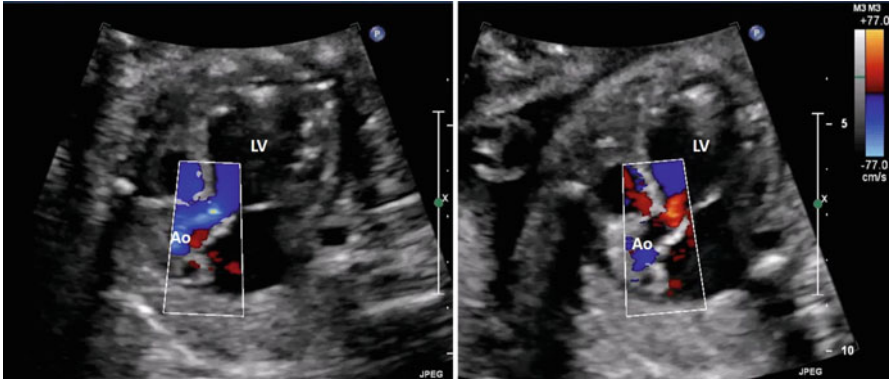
Immediate results after successful fetal aortic valvuloplasty as assessed by echocardiography. *Left panel:* long-axis view of the left ventricular outflow tract showing unequivocal antegrade flow (in blue) across the aortic valve with color flow mapping. *Right panel:* same view of the left ventricular outflow tract showing aortic insufficiency (in red) with color flow mapping. *Abbreviations:* LV left ventricle, Ao ascending aorta
